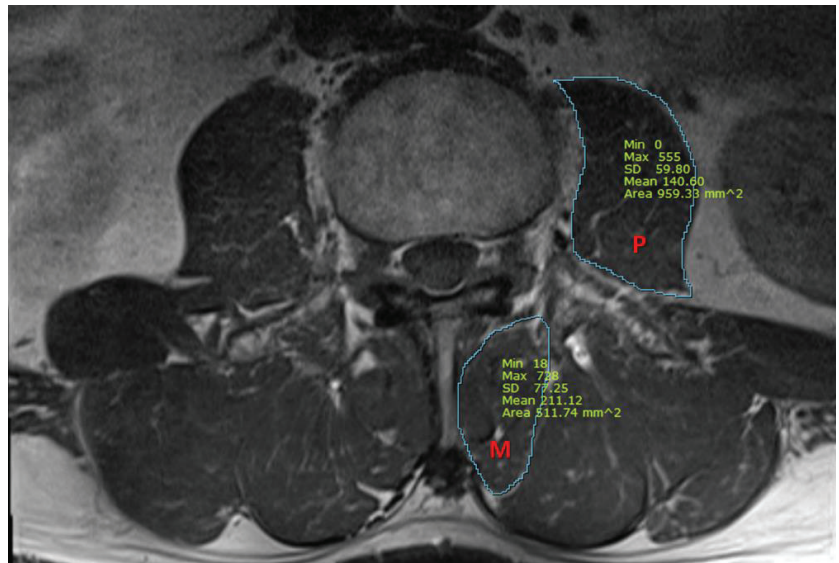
A representative magnetic resonance image for the measurement of cross-sectional area (mm^2) of the psoas and multifidus muscles. P, psoas muscle; M, multifidus muscle.
